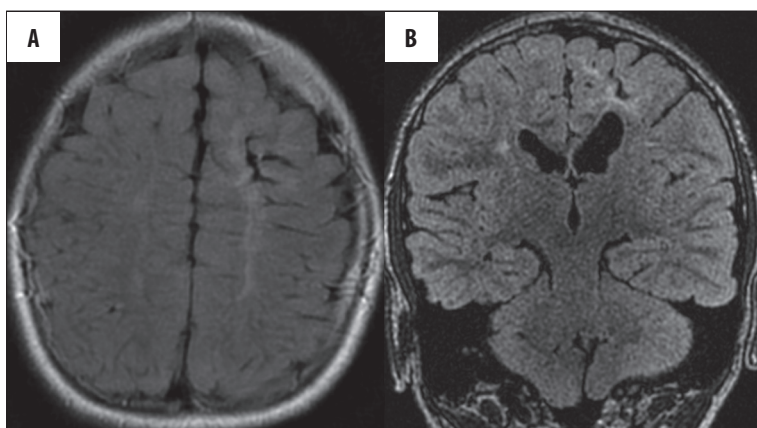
Involvement of the subcortical white matter in a child born after 36 week of gestation. Atypical asymmetric lesions. (A) FLAIR,ax; (B) CUBE/3D/FLAIR,cor.
